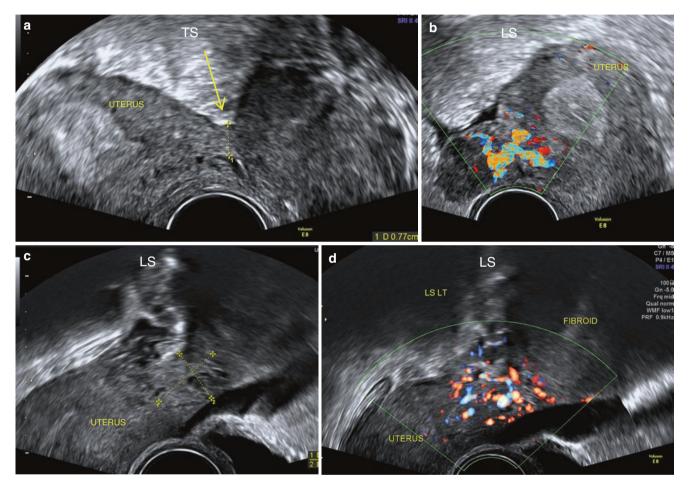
Subserous pedunculated fibroids. (a) A large fibroid seen attached to the uterus through an isoechoic, 7.7 mm broad pedicle (*arrow*). (b) A subserous fibroid with flow approaching it from its origin in the posterior wall of the uterus. (c, d) A large, subserous fibroid arising from the anterior fundal wall of the uterine fundus. A broad pedicle is seen on greyscale and with Doppler
